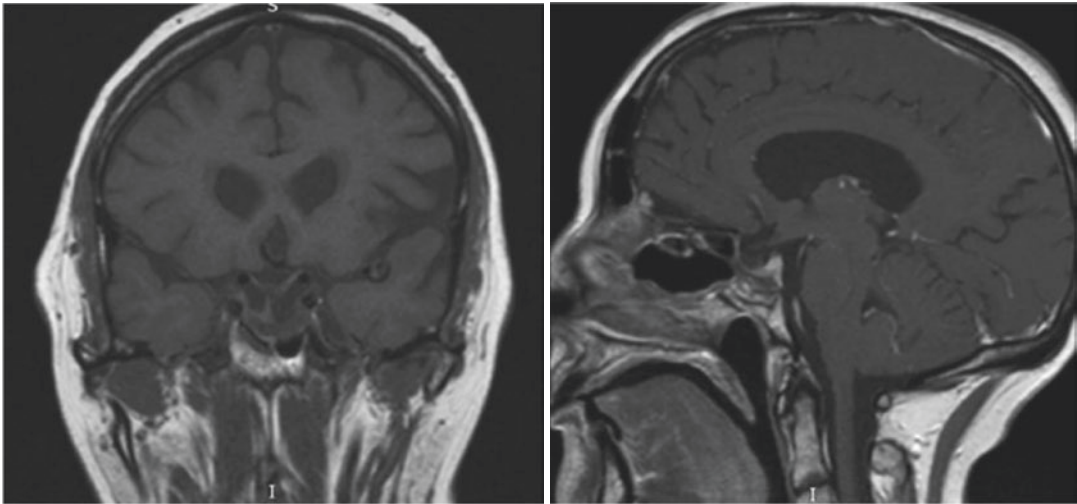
Post-operative MRI
